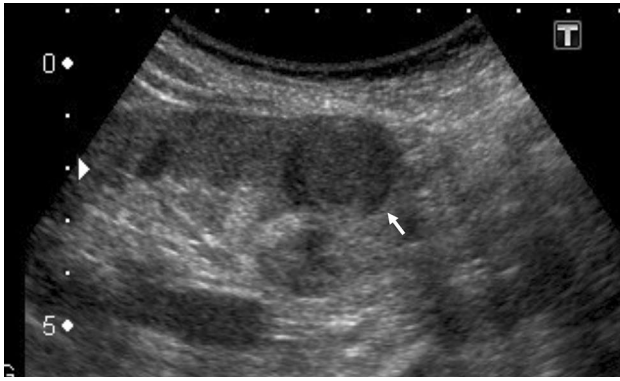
Abdominal ultrasonography shows a hypoechoic mass in the right kidney. The mass is bounded by a hypoechoic band regarded as representing a capsule (arrow)
